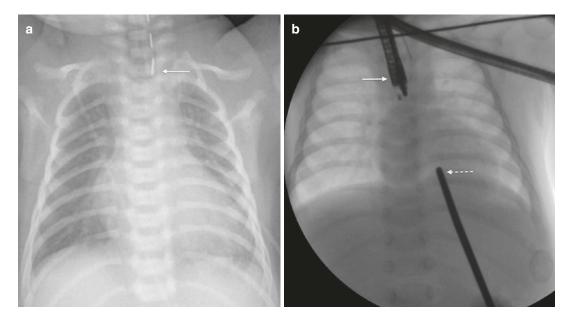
Oesophageal atresia. (a) Radiograph of the chest and abdomen demonstrates a Replogle tube in the lower cervical oesophagus (*arrow*) and a paucity of abdominal bowel gas. (b) Selected fluoroscopy image
